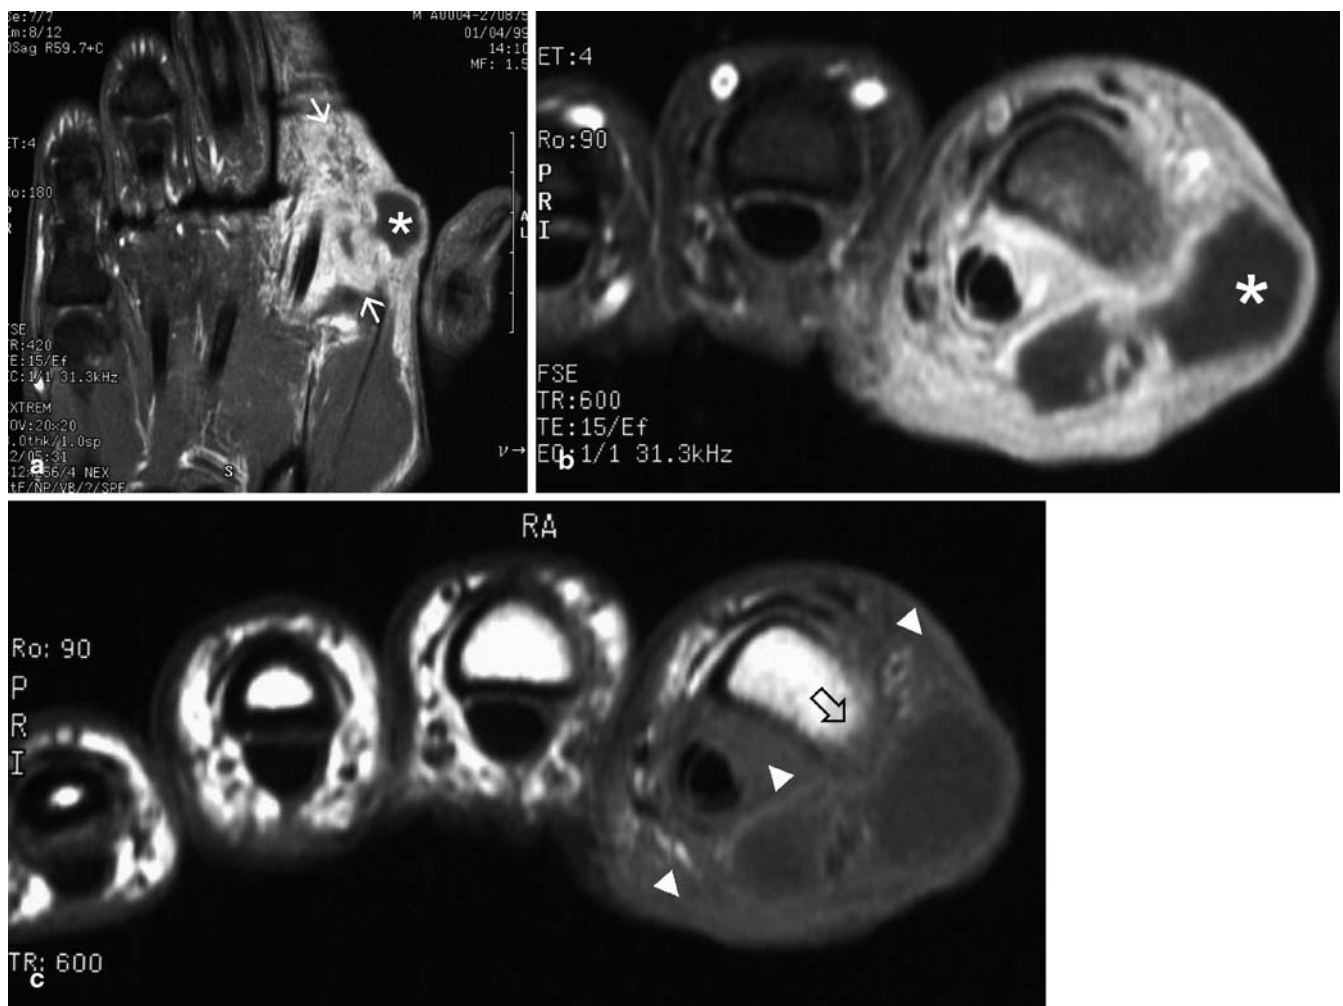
A Coronal T1-weighted fat-saturated contrast-enhanced MR image (TR: 420, TE: 15) shows a focal fluid collection (*) as well as diffuse soft tissue involvement, with marked contrast enhancement (white arrow). B Axial T1-weighted fat-saturated contrast-enhanced MR image (TR: 600, TE: 15) shows marked diffuse soft tissue enhancement with a polylobulated abscess (*). Associated
